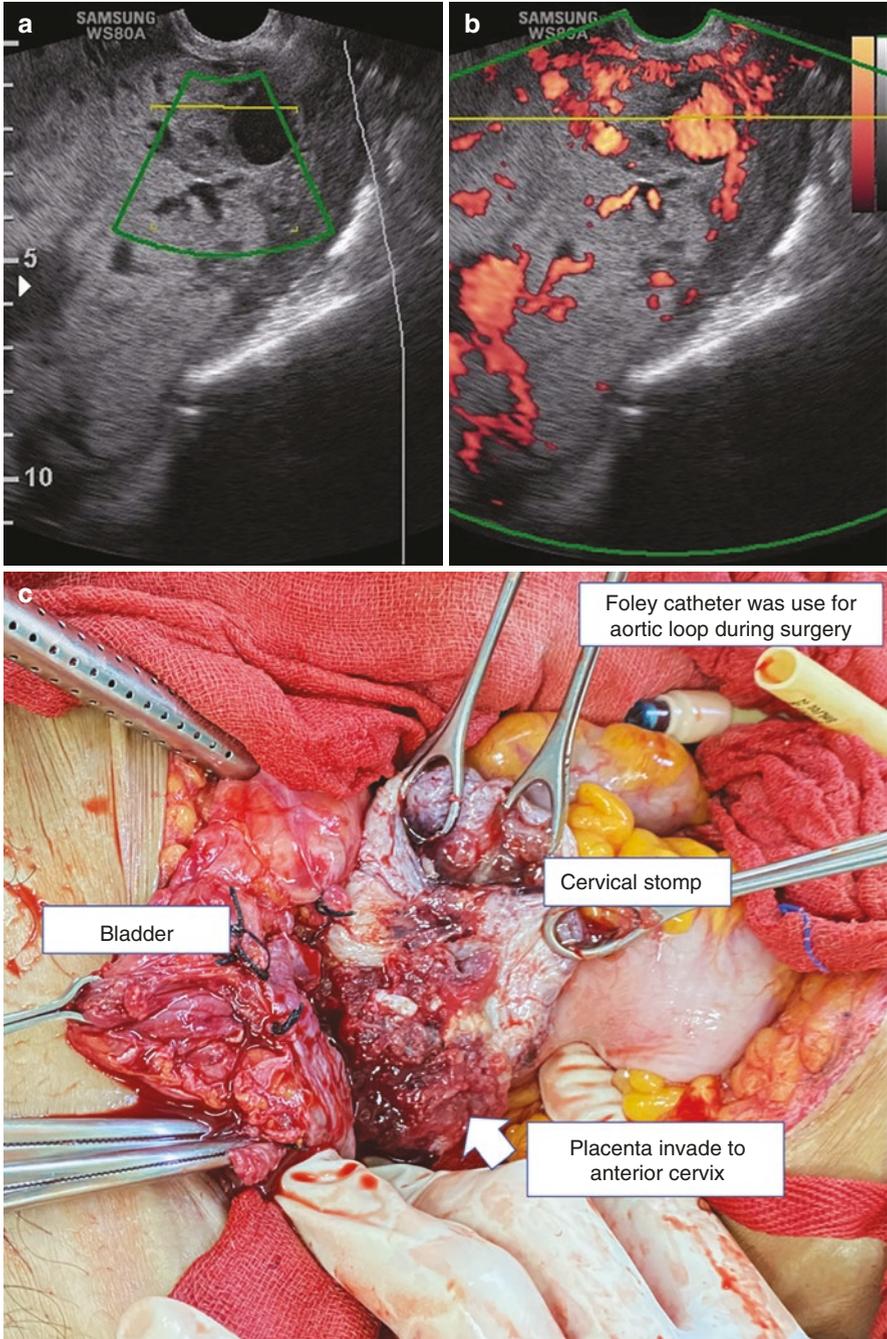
(a) Transvaginal ultrasound shows the placenta invading the anterior cervix with abnormal lacunae. (b) Cervical hypervascularity and intracervical lacunae show S2 uterine sector of uteroplacental vascularity. (c) Cervical invasion (white arrow) during modified subtotal hysterectomy with abdominal aortic loop using Foley catheter
